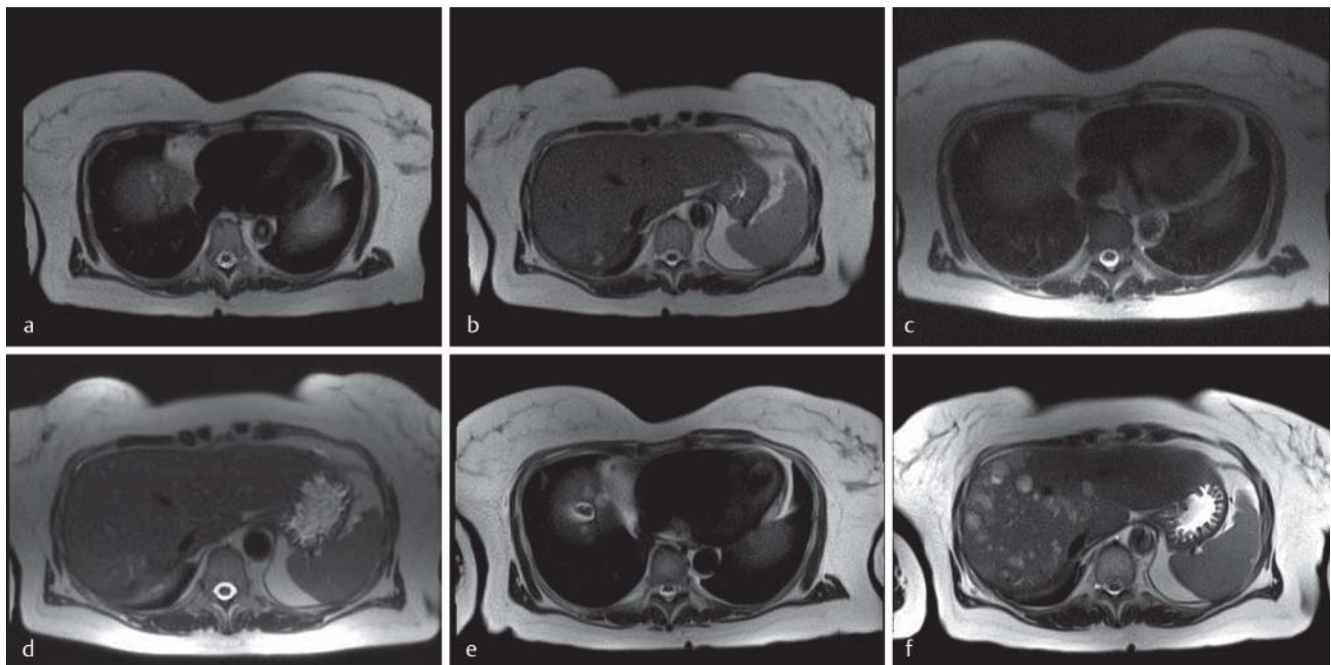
Magnetic resonance images (T2 haste) of a patient with diffuse liver metastases from malignant melanoma a, b and the corresponding images taken 4 weeks after chemosaturatation-PHP c, d with significant reduction in the size of the metastases (partial response). After two treatments with laser-induced thermotherapy, full hepatic remission, which lasted for 10 months, occurred. Regional disease recurrence (>50 single lesions) was documented 13 months after treatment e, f.
